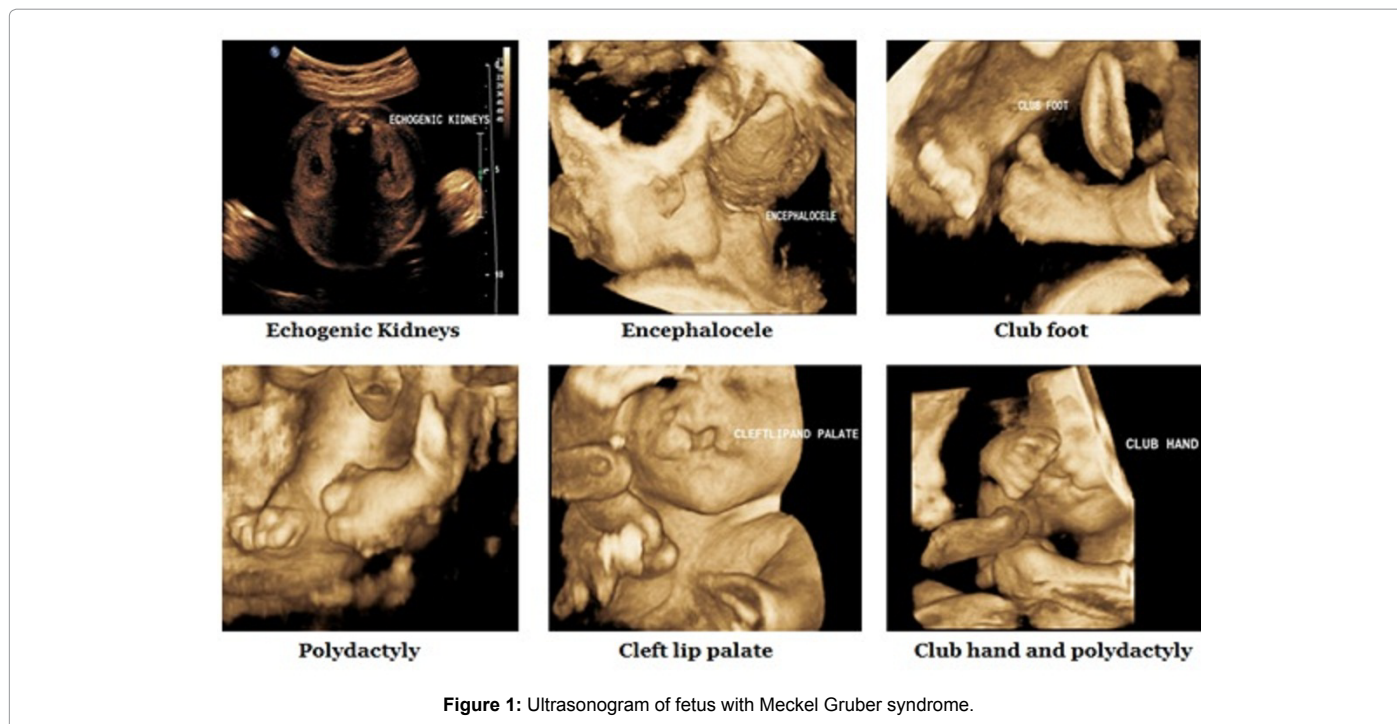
Ultrasonogram of fetus with Meckel Gruber syndrome.
